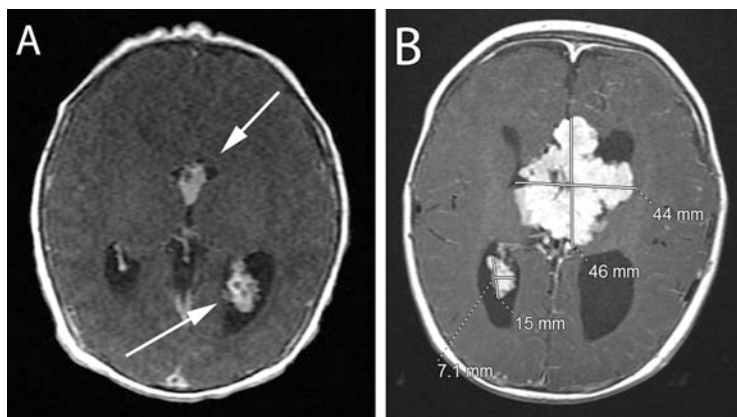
A rapidly progressing multifocal tumor in an infant is shown. (a) Axial T1-weighted MRI image with gadolinium contrast in a newborn shows a tumor in the third ventricle and another in the left lateral ventricle. The left ventricular tumor was removed at 3 months of age. By 6 months of age, the third ventricular tumor grew significantly (b)
